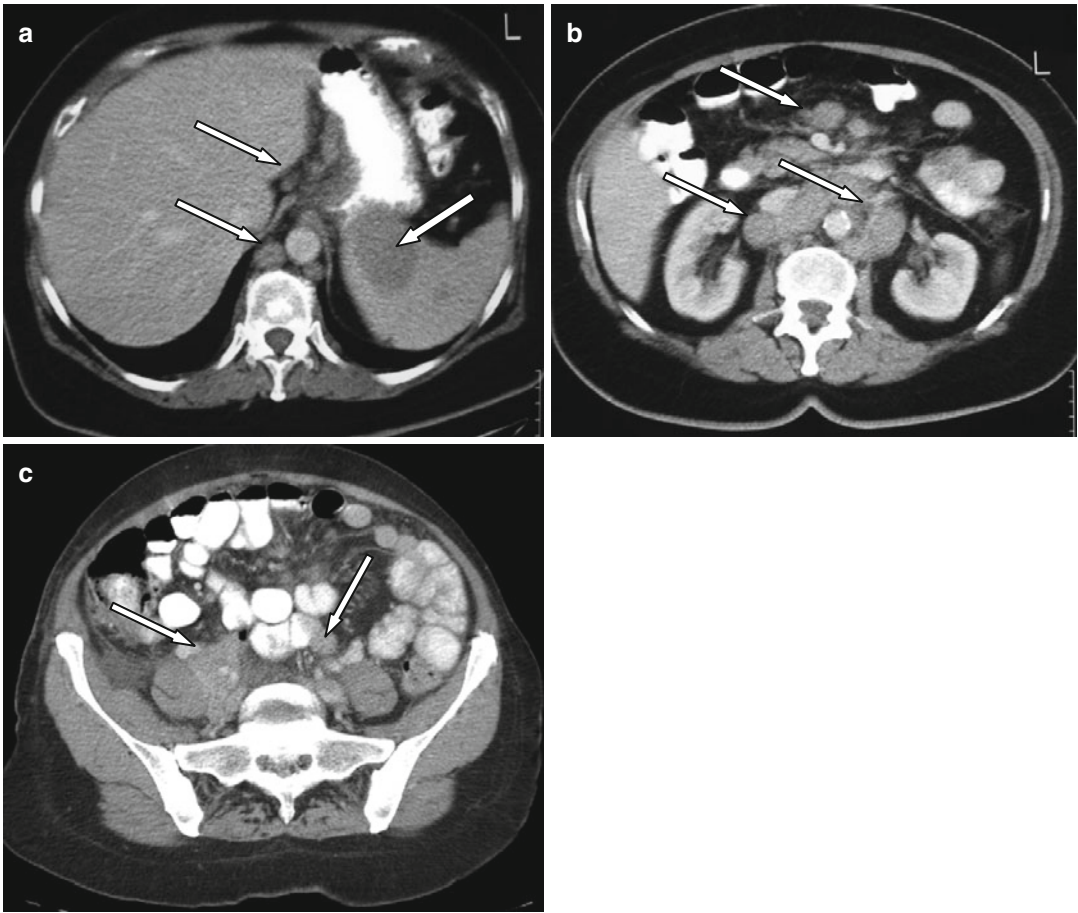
(a) Axial CT image in a patient with lymphoma with enlarged hepatogastric and retrocrural lymph nodes and metastatic splenic lesions (*arrows*). (b) Axial CT image at the level of the renal hila shows multiple enlarged
